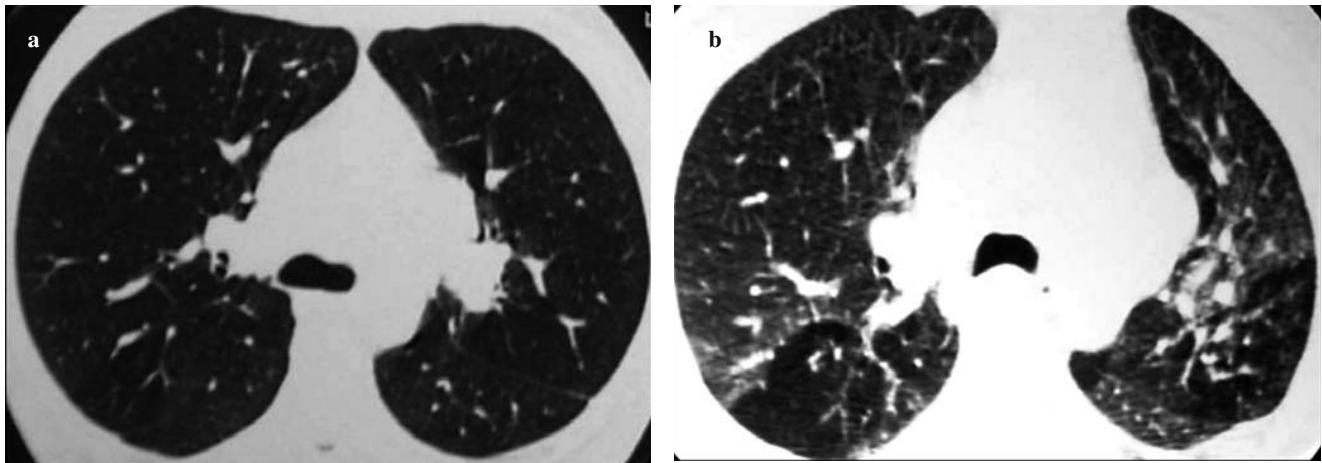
On inspiratory high-resolution computed tomography (HRCT) at the level of the carina, only some small nodules can be seen in a peribronchovascular distribution; b areas of air trapping are depicted on expiratory HRCT in both lungs in a segmental distribution.
